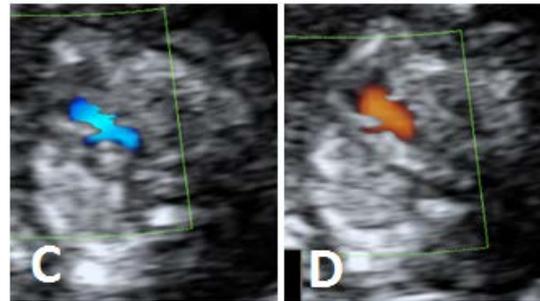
A, B: A narrow width of the left ventricle in comparison to that of the right ventricle in color (A) and power Doppler (B) at the level of the four-chamber view of the heart.
